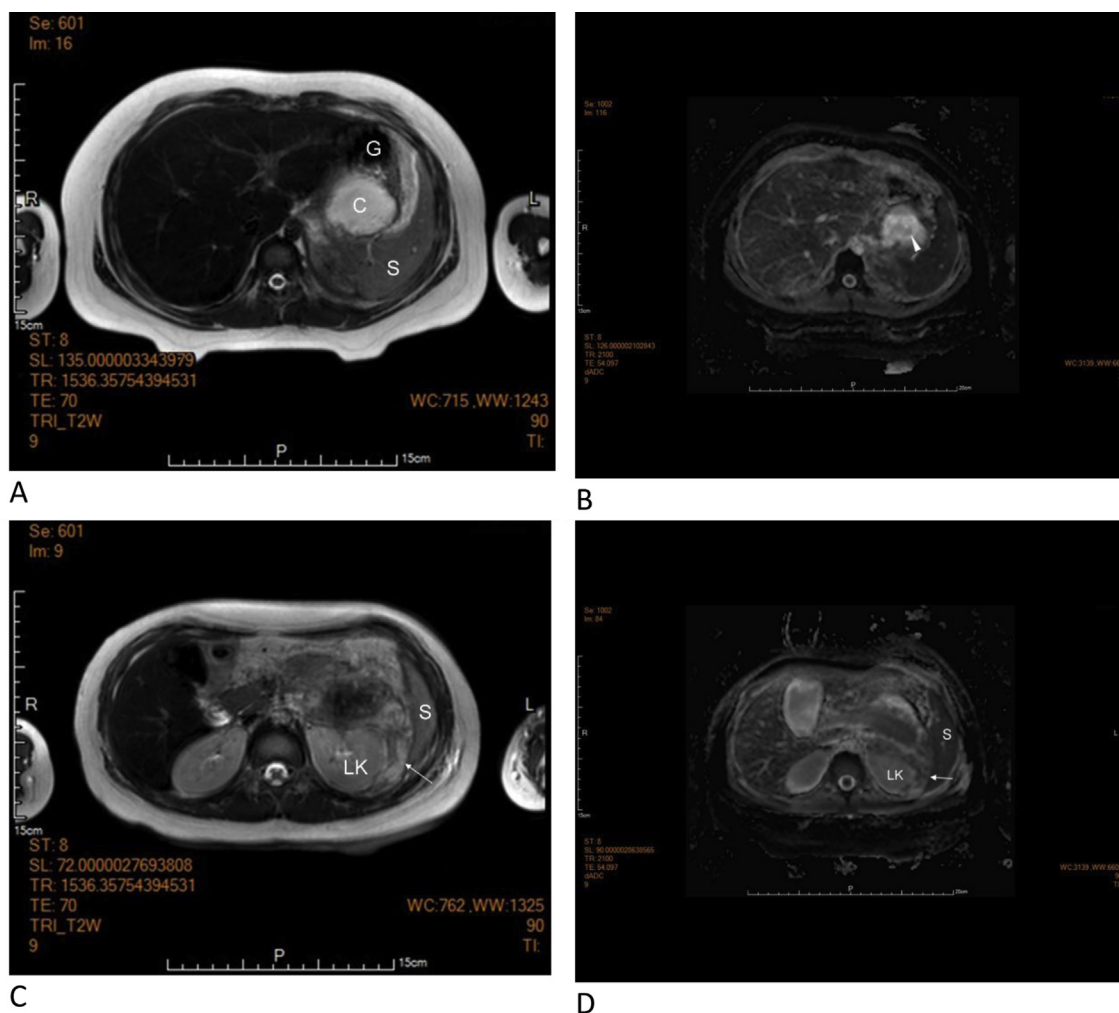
Magnetic resonance imaging (MRI) of abdomen done 14 days after the onset of abdominal pain. A 6 cm \times 4-cm well-defined cystic lesion near the pancreas tail with high signal in (A) T2-weighted image (T2WI) and (B) low signal in apparent diffusion coefficient sequence (ADC) (arrowhead), indicating infectious pseudocyst. (C) Focal high signal in T2WI and low signal in ADC (D) at left splenorenal recess, favoring inflammatory ascites (arrows). C = pseudocyst; G = stomach; LK = left kidney; S = spleen.
